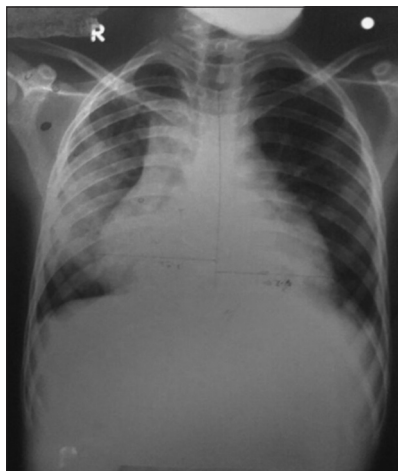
The chest radiograph shows non homogenous opacities involving the right middle and lower lung zones with cardiomegaly (cardiothoracic ratio: 0.68) suggestive of pericardial effusion
